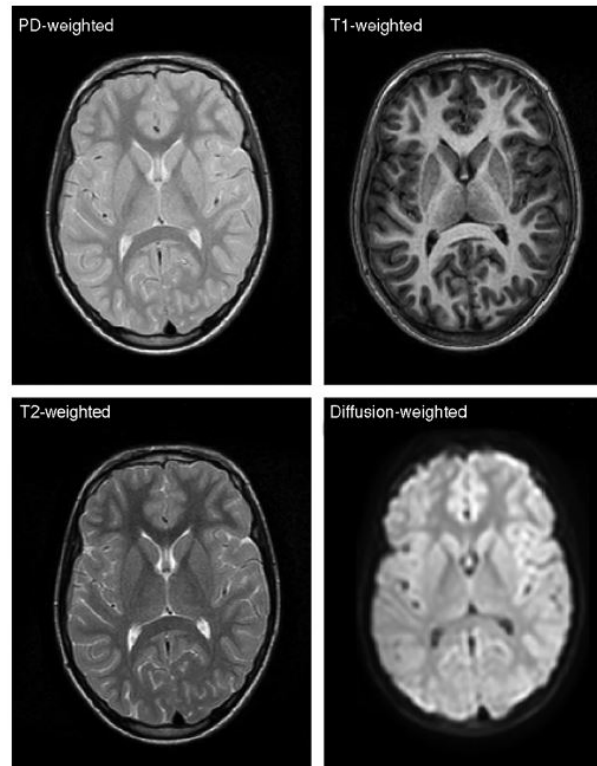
Axial proton density-weighted (PD-weighted), T1-weighted, T2-weighted, and diffusion-weighted images acquired from one healthy adult volunteer [25].
